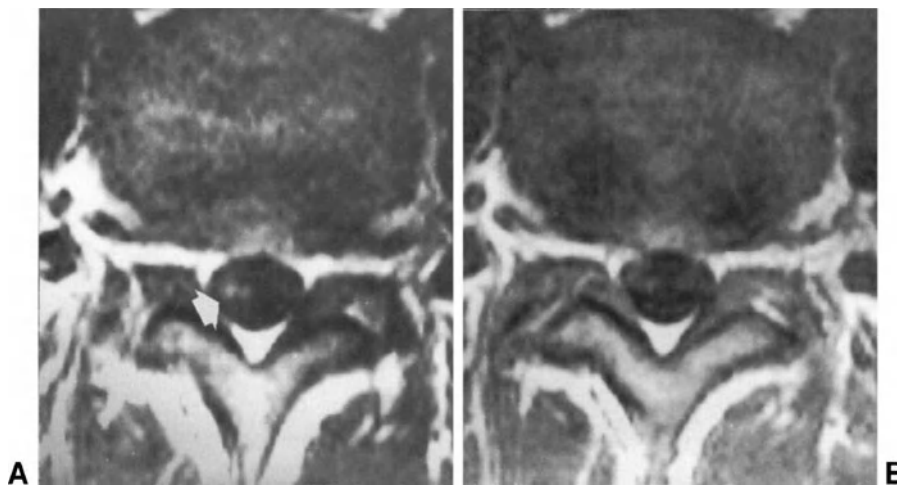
Spin-echo T1-weighted axial MR images after administration of gadolinium obtained 1 month (A) and 3 months (B) after discectomy. After 1 month of surgery, two hyperintense nerve roots are visible in the right portion of the thecal sac (arrow). The hyperintensity has disappeared after 3 months.
